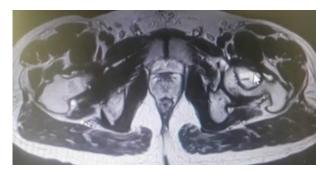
MRI pelvis axial cut showing homogeneous enhancing lesion which is hyper intense on T2 W.
